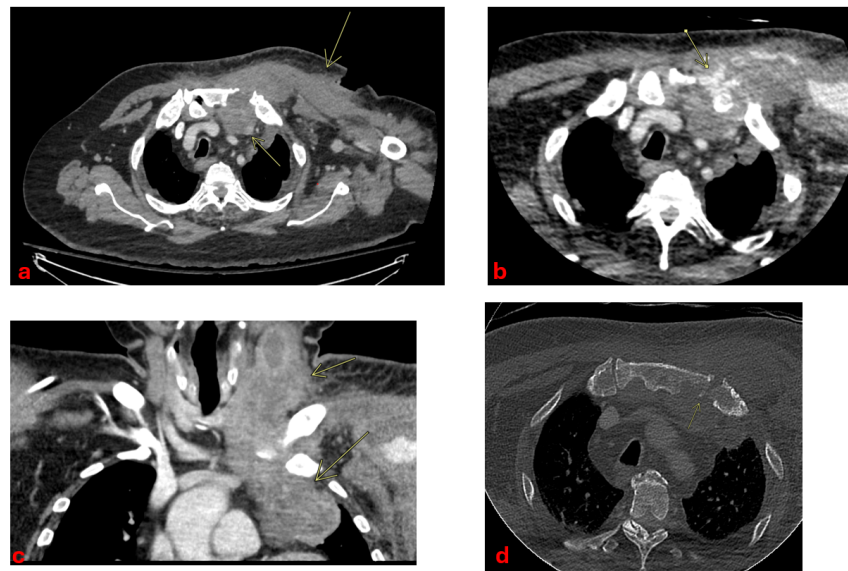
The post-contrast CT scan of the chest and neck reveals erosion and destruction of the left sternoclavicular joint. Additionally, a large, heterogeneous necrotic soft tissue mass extends both superiorly into the neck and anteriorly into the mediastinum. Notably, there is active contrast enhancement from the left internal thoracic artery and pooling in an anterior chest wall collection.
